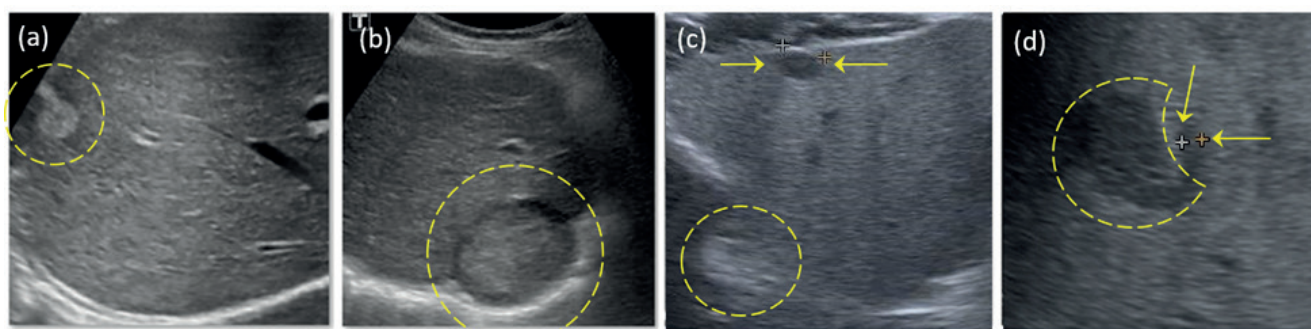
Ultrasound images with and without markers. HEMs and HCCs show inside a dashed circle. a: HEM without a marker, b: HCC without a marker, c: a marker for hepatic cyst in HEM image, d: a marker for vessels near HCC.
